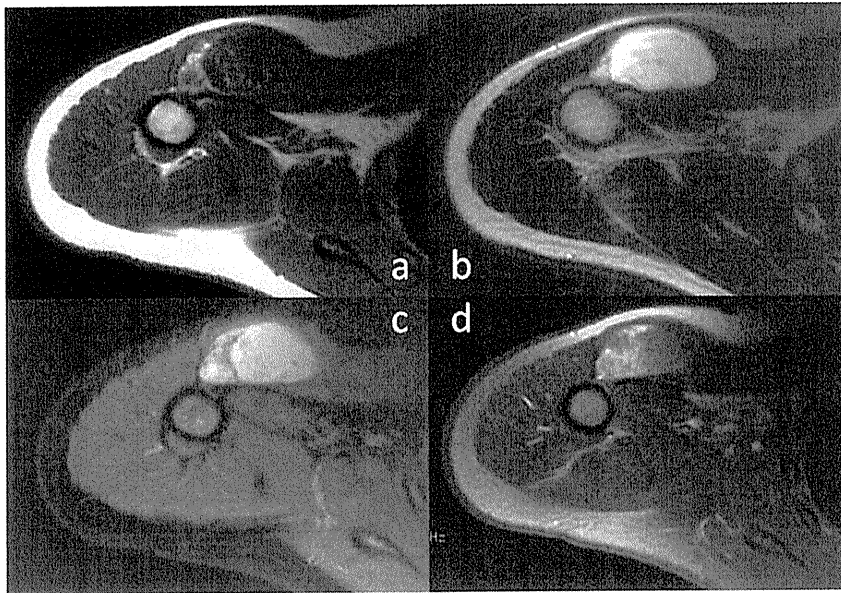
MRI of the right shoulder of a 12 year-old female.
